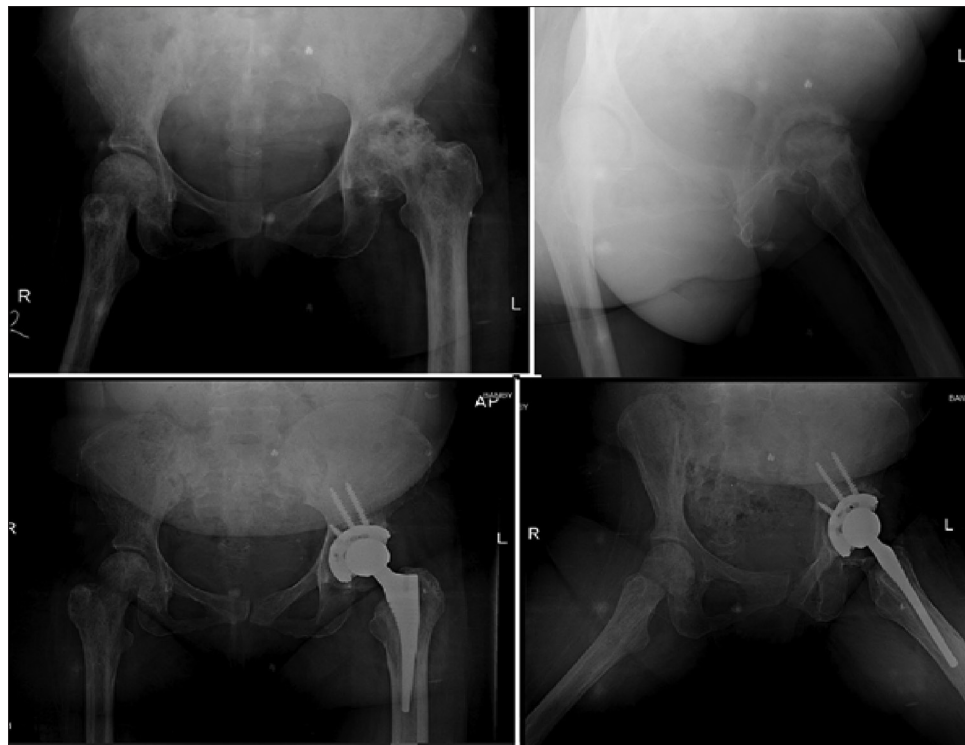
Pre-operative and 3-month post-operative radiographs in anteroposterior and lateral views
